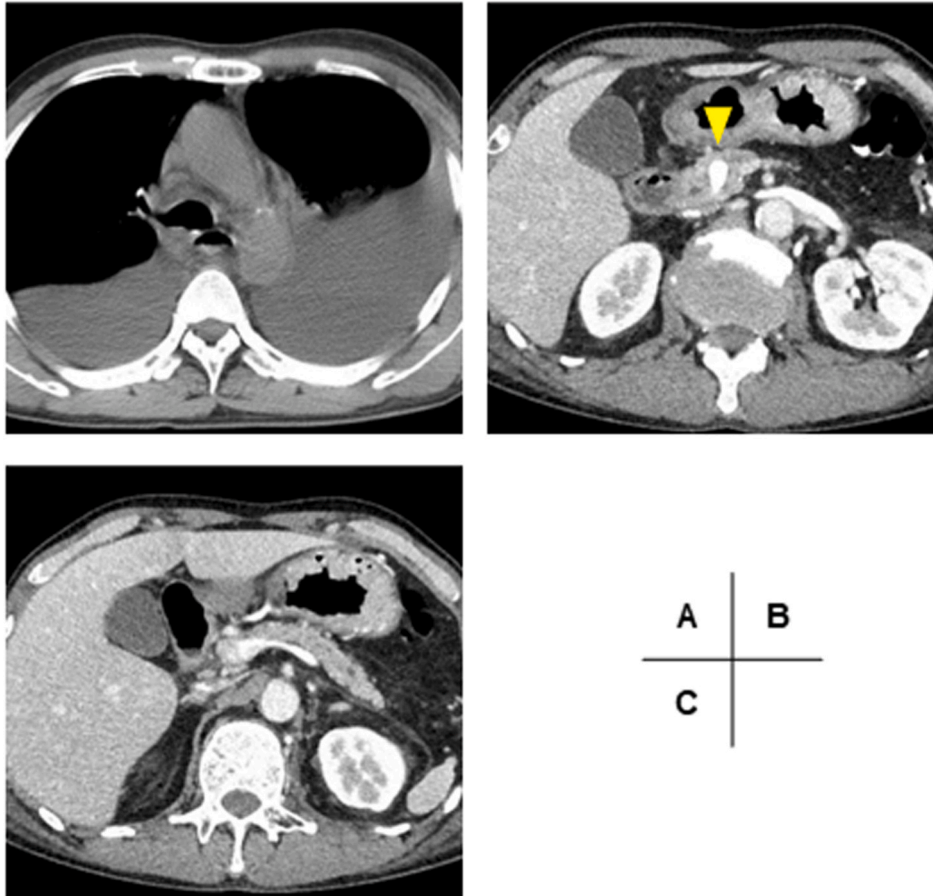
A 58-year-old male with dyspnea was referred to our emergency department. Cross-sectional imaging revealed bilateral pleural effusion (A). Although pancreatolithiasis was present in the head of the pancreas (arrowhead) (B) with atrophic pancreas diagnosed as chronic pancreatitis, obvious pancreatic fistula was not observed on contrast-enhanced computed tomography (C).
